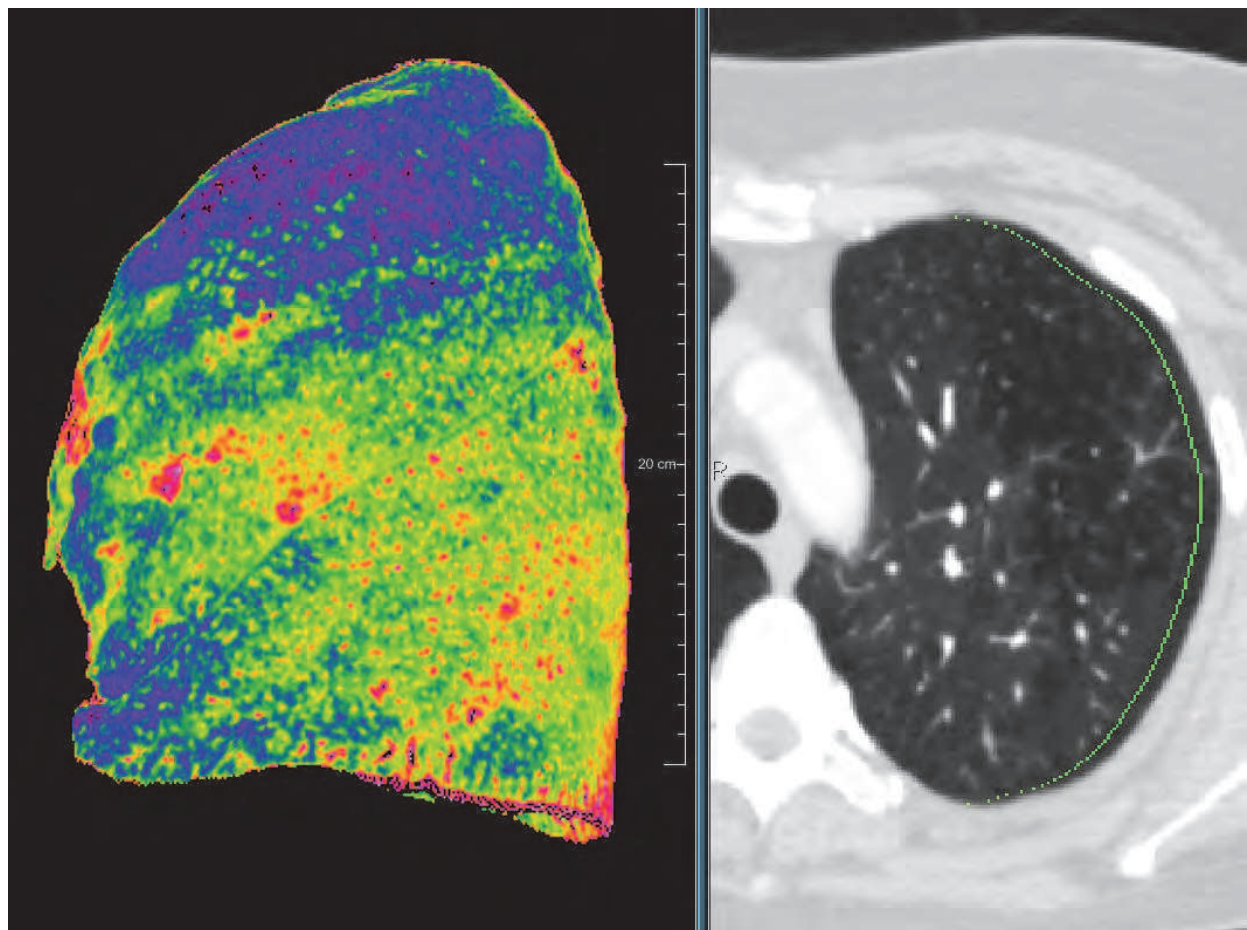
The conventional display of CT data on flat sections provided by the data set is complemented here by the depiction of all image points that, similar to the layers in an onion, are all at a constant distance to the surface of the organ. On the left, you can see a superficial depiction of such a layer, located at approx. 10 mm from the internal thoracic wall. Lung density is colour coded. On the right, you can see the corresponding conventional view.
